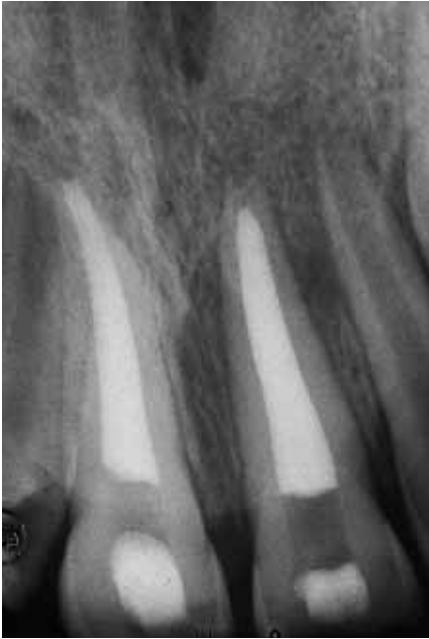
Radiographic examination after having completed the endodontic treatment.
